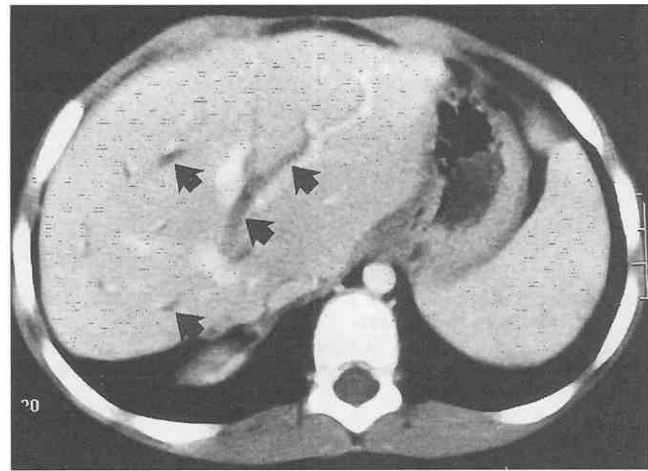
Biliary stricture following segmental liver transplantation. Contrast-enhanced CT image in a child who has developed a focal anastomotic stricture at the biliary-to-bowel anastomosis. Tubular low-attenuation structures (arrows) correspond to dilated intrahepatic biliary ducts. (Courtesy of Dr. Cynthia K. Rigsby, Children's Memorial Hospital, Chicago.)
